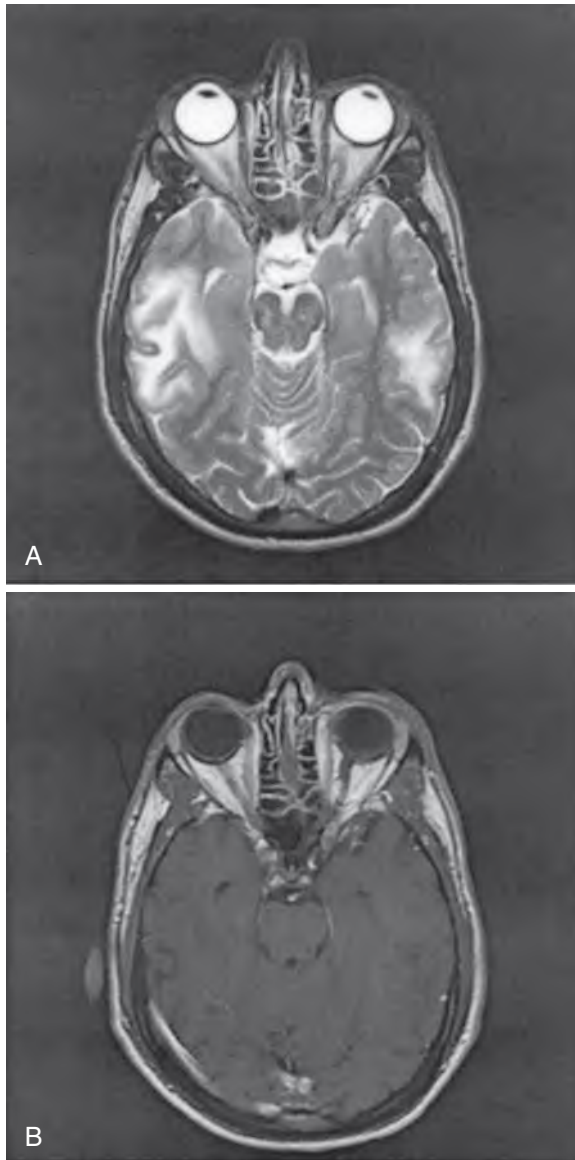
Brain magnetic resonance images of a 43-year-old man with progressive multifocal leukoencephalopathy. (A) Prominent areas of high signal intensity are present in the subcortical white matter of both temporoparietal lobes on T2-weighted images. (B) The affected areas are hypointense on T1-weighted images, do not enhance with gadolinium, and are not associated with mass effect or edema.
